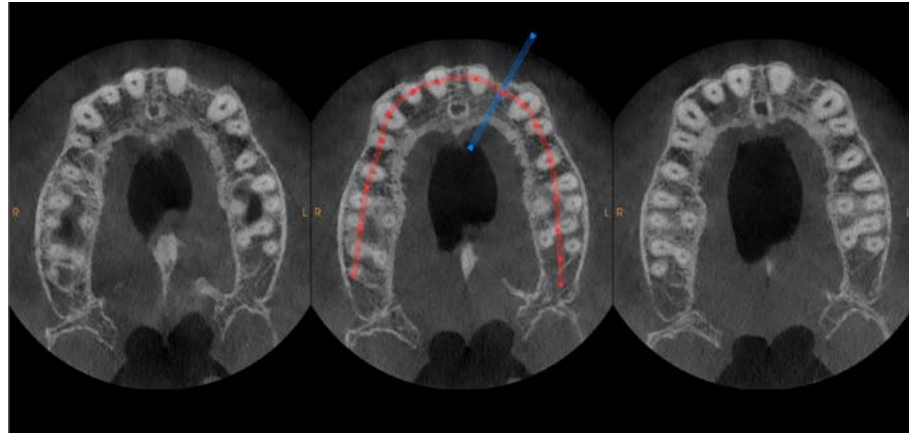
Arch creation derived from CBCT scan
